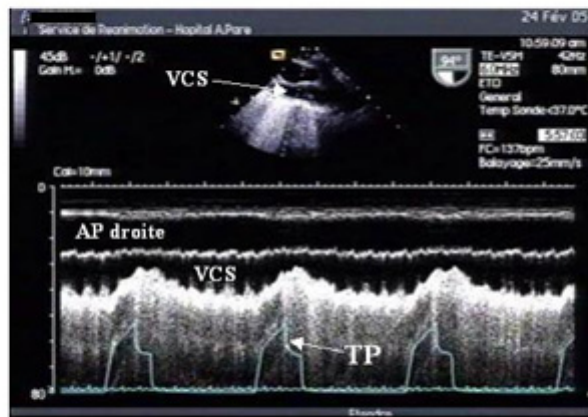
Partial collapse of the SVC seen on a longitudinal view recorded using two-dimensional and M-mode echocardiography. This recording was made in a mechanically ventilated patient with circulatory insufficiency and suggests the presence of hypovolemia. AP: airway pressure; PA: pulmonary artery.
